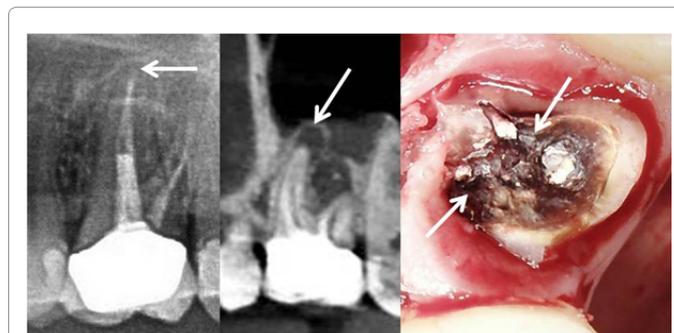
Comparison of two techniques: 2D-OPG and 3D-DVT/CBCT. 3D-DVT/CBCT clearly shows AP (centre panel) when compared to the 2D-OPG (left panel). Right panel shows dentine blackening caused by biogenic amines after removal of the crown.
